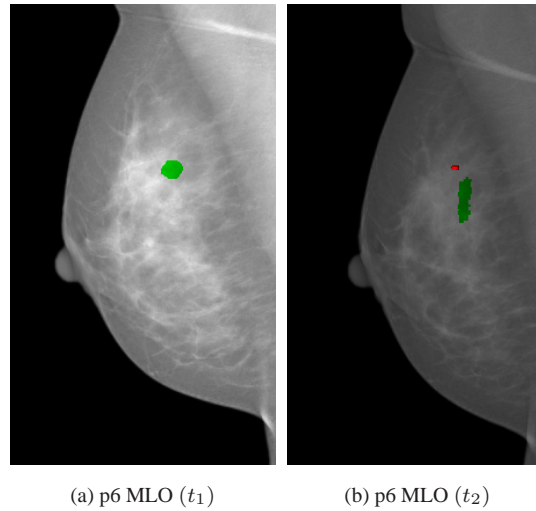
Temporal registration results for the MLO view of patient p6. The X-ray annotation at timepoint t_1 is shown in green, as well as its projection on the second mammogram. The clip of p6 at timepoint t_2 is shown in red. Their overlap is yellow. The error is $6mm$.
